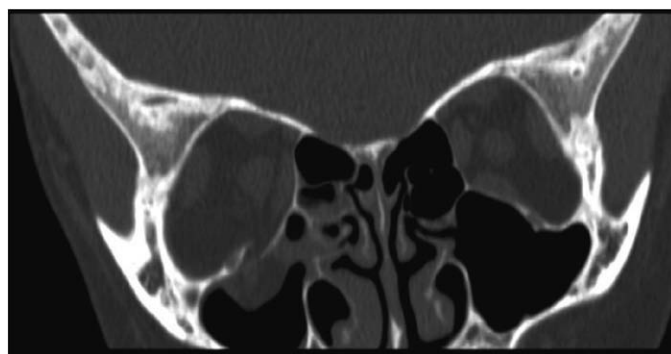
Coronal computed tomographic section showing right orbital trapdoor fracture with displacement of inferior rectus muscle through fracture. Note the rounded shape (increased height-to-width ratio) of the muscle belly compared with the unaffected eye.
